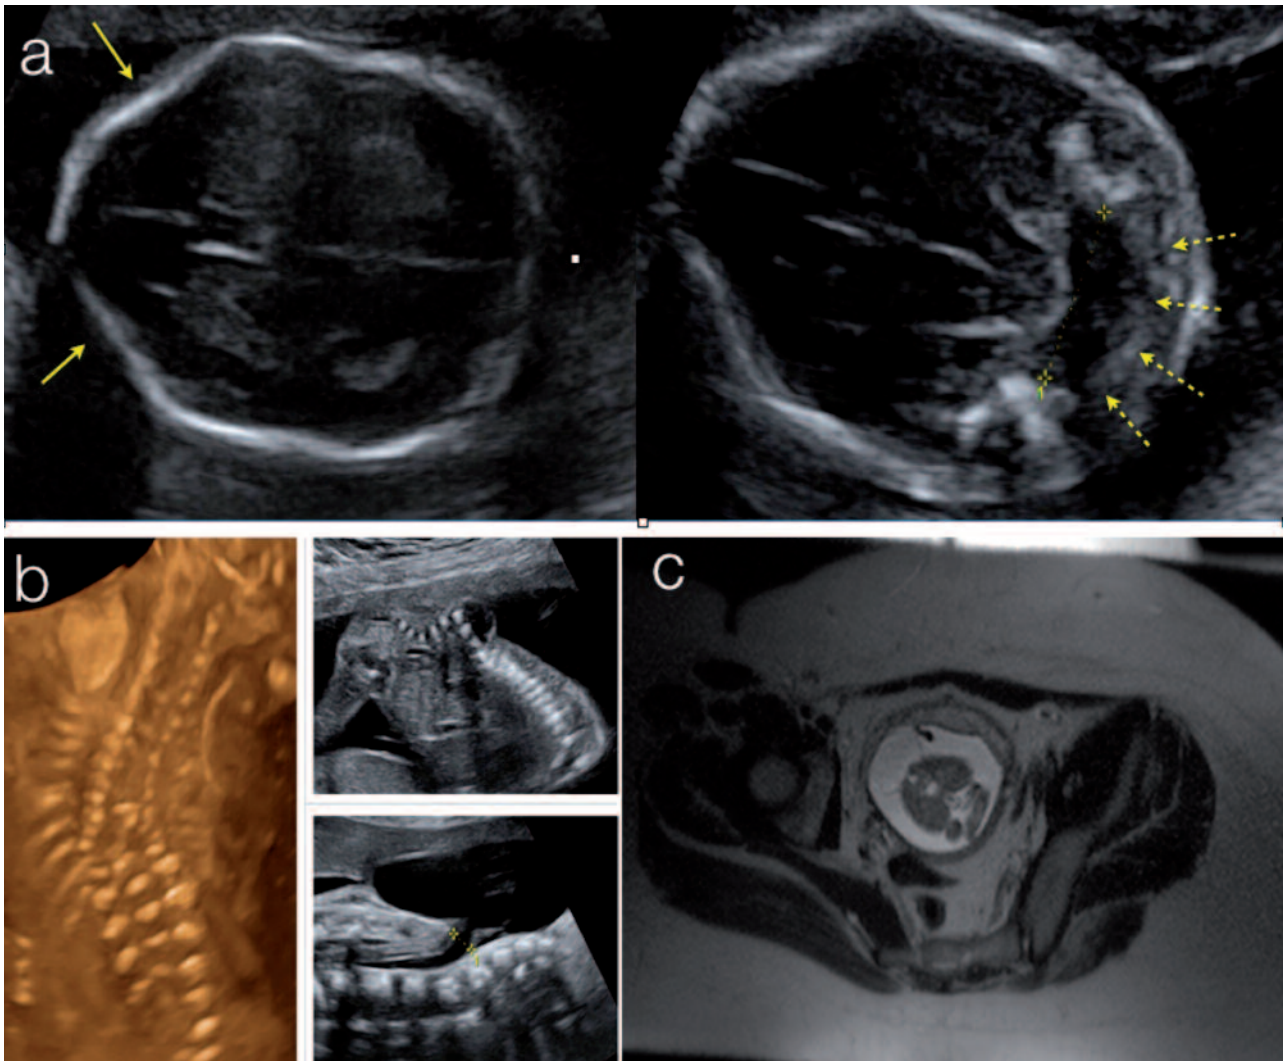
Spinal neural tube defects are mainly detected by the presence of the “lemon” (yellow arrows) and “banana” sign (dashed arrows), or scalloping of the frontal bones and obliteration of the cisterna magna with hypoplasia of the cerebellum (a). Severe lesions are characterized by spinal dysraphism and are more easily detectable at the level of the spine it self (b). MRI axial view of a fetal meningomyelocele in a mother with a body mass index of 42. Gestational age 20 weeks (c).
